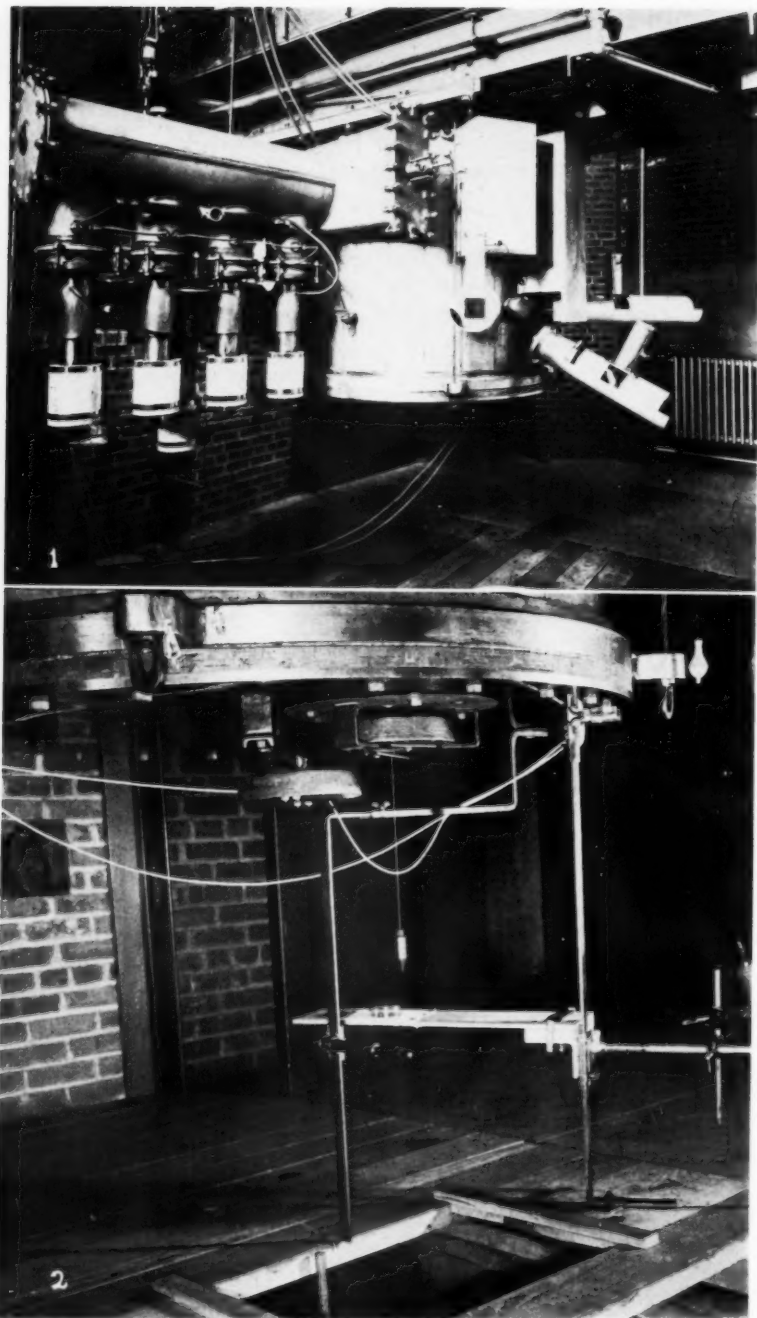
Vacuum chamber of Sloan x-ray generator. Three of four side ports fitted for deep therapy can be seen at the right; vacuum pumps at the left. The sides of the vacuum tank are covered with 2 inches of lead, with 3 additional inches on the side toward the control room. In a copper shield above the vacuum chamber are mounted two continuously pumped oscillator tubes capable of supplying peaks of over 100 kilowatts at 6 megacycles to the primary of the resonance transformer in the vacuum chamber.
